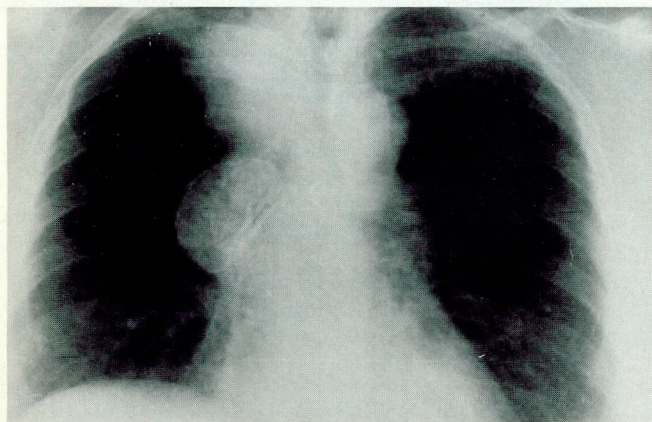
Posteroanterior radiograph of the chest reveals large calcified right hilar lymph node that caused airway obstruction in a patient with Hodgkin's disease following radiation therapy.
